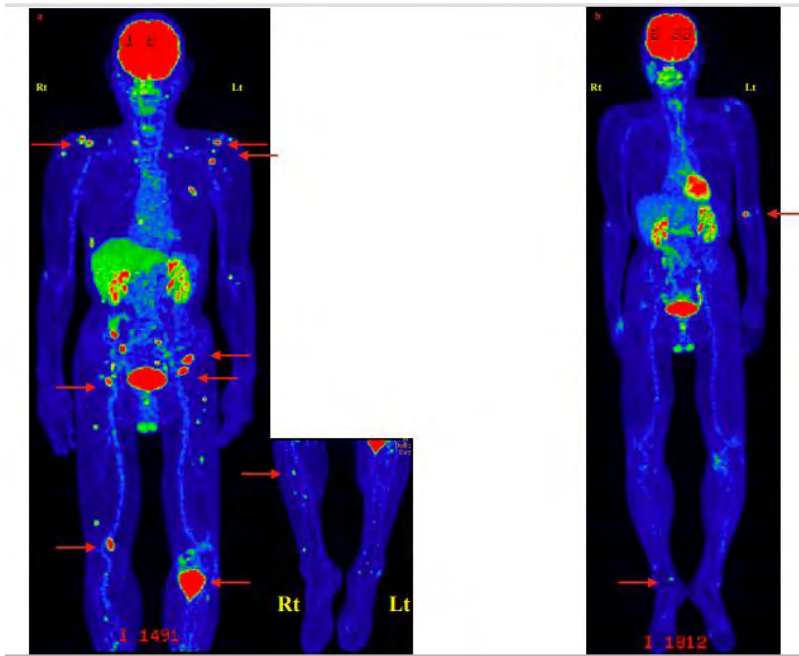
PET-CT findings, a. (Before treatment): Multiple abnormal accumulations in bone regions. (indicated by the red arrow.) b. (After end of the first cycle of mLSG therapy): Disappearance of the abnormal accumulation seen before the treatment, but new accumulation in the left humerus and right tibia. (indicated by the red arrow.)
